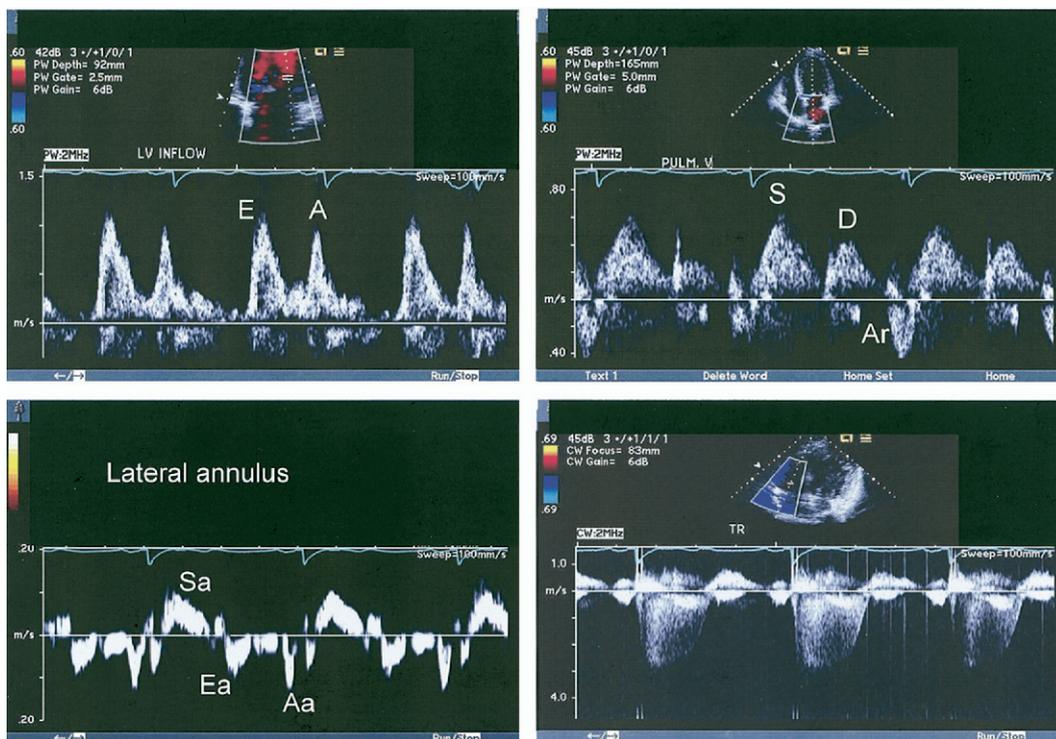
(Upper left) Mitral left ventricular (LV) inflow; (upper right) pulmonary venous flow; (lower left) tissue Doppler velocities at lateral side of mitral annulus; (lower right) tricuspid regurgitation (TR) jet by continuous wave (CW) Doppler. Mitral inflow is pseudonormal (E/A ratio of 1), and systolic/diastolic (S/D) velocity (and time velocity integral) ratio >1 in the pulmonary veins. However, atrial reversal (Ar) velocity in pulmonary venous flow is increased both in amplitude and duration, indicating increased LV end diastolic pressure. The early diastolic (Ea) velocity is reduced and Ea/late diastolic (Aa) velocity ratio is <1, indicating abnormal LV relaxation. The E/Ea ratio is increased to 12.5, indicating increased LV pre-A pressure. Peak TR velocity = 2.8 m/s, indicating an RV and pulmonary artery (PA) systolic pressure of at least 31 mm Hg.
